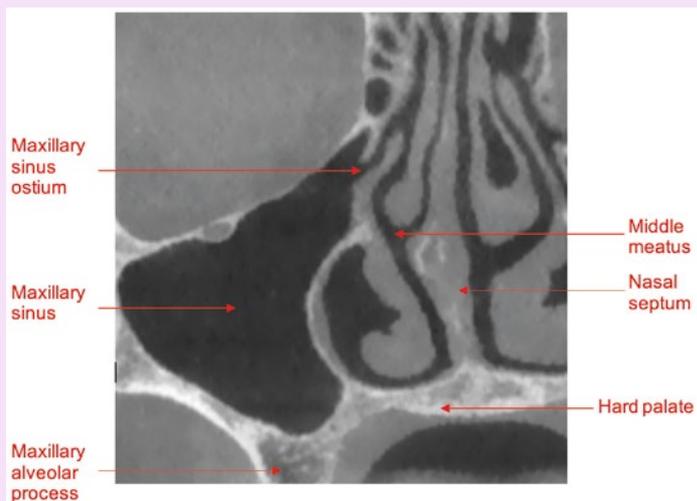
Labeled cone beam computed tomography (CBCT) coronal slice demonstrating the relationship of the maxillary sinus to the nasal cavity and other surrounding structures
